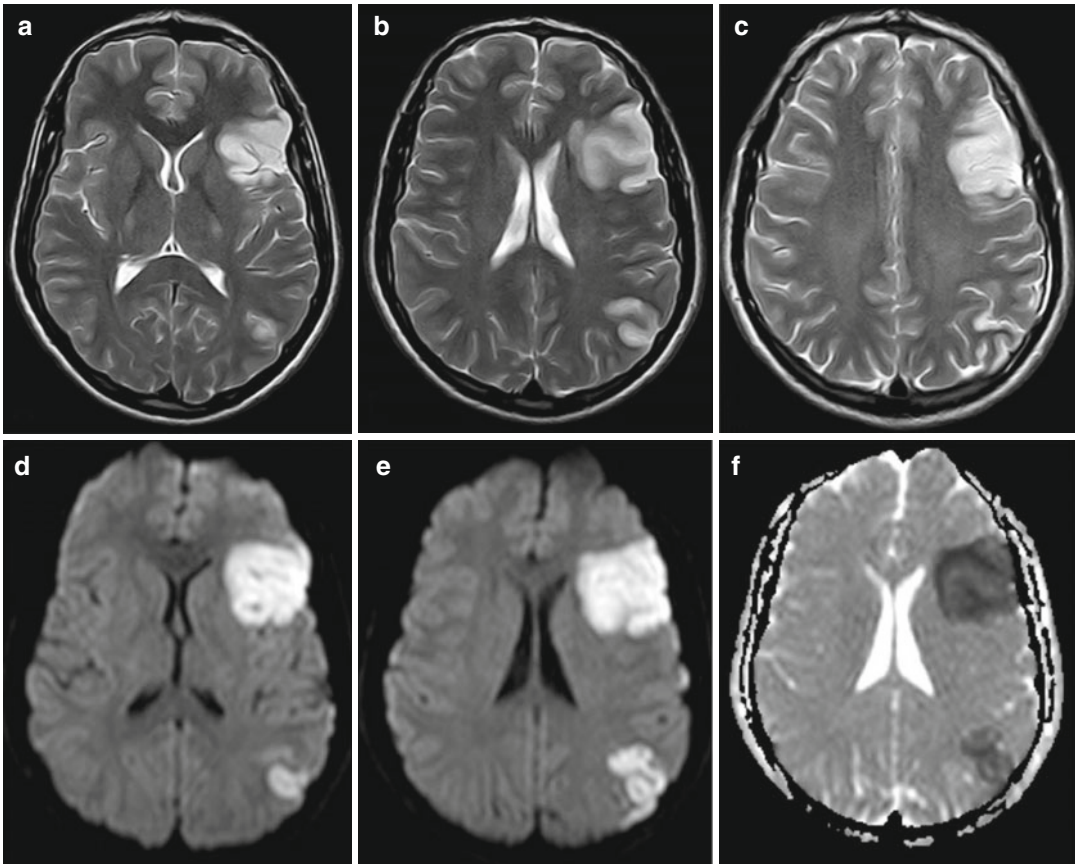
Acute ischemic stroke. Axial T2-weighted images, (a–c), demonstrate cortical-subcortical hyperintensities in the left frontal-opercular and in the left
